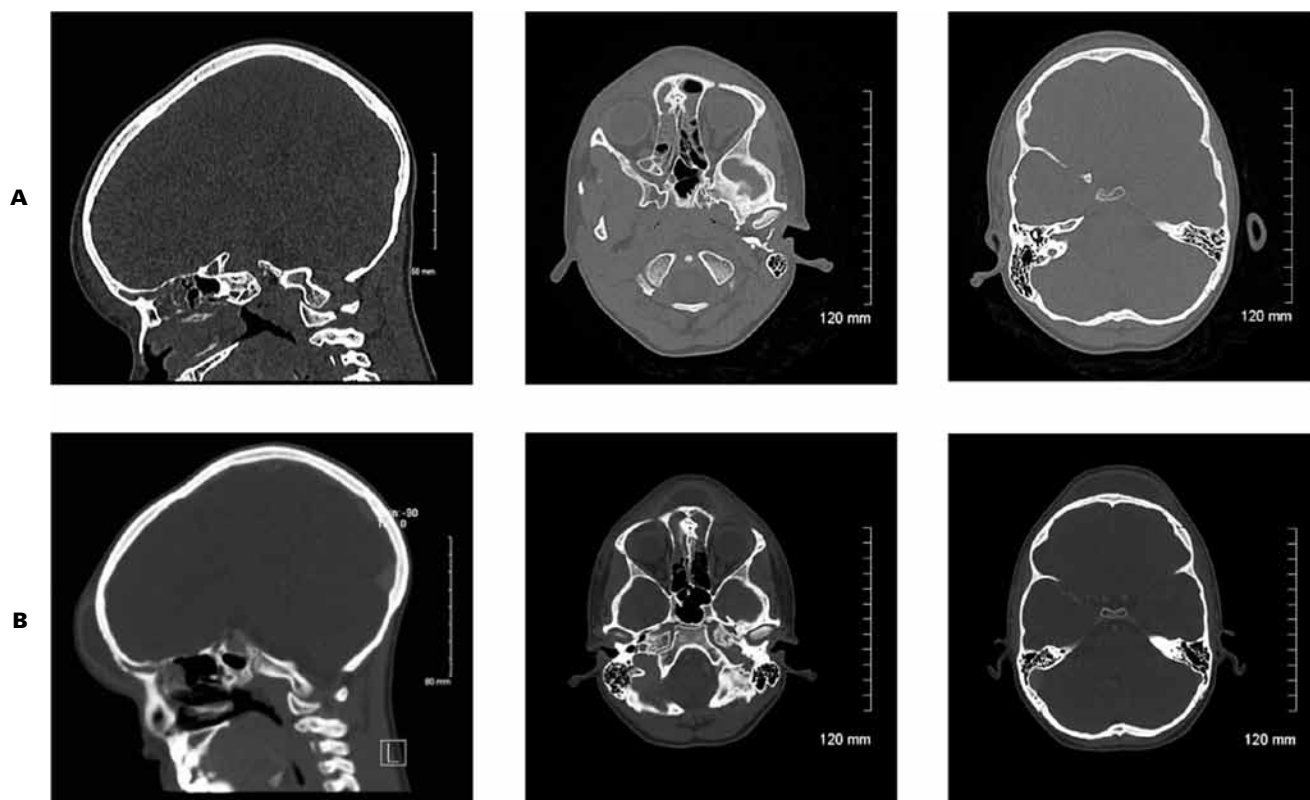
A: CT images obtained after patient presented with a prodrome of upper respiratory infection and onset of forehead swelling. Images reveal partial opacification of frontal and ethmoid sinuses. B: CT images obtained after antibiotic therapy and progression of forehead swelling. Images reveal complete bilateral opacification of frontal sinuses associated with moth-eaten appearance of the anterior table of the frontal bone and a subperiosteal abscess.
